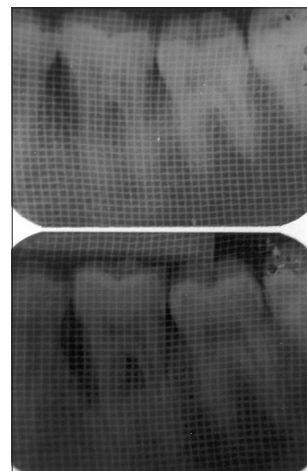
Preoperative and postoperative radiographs - molar region
